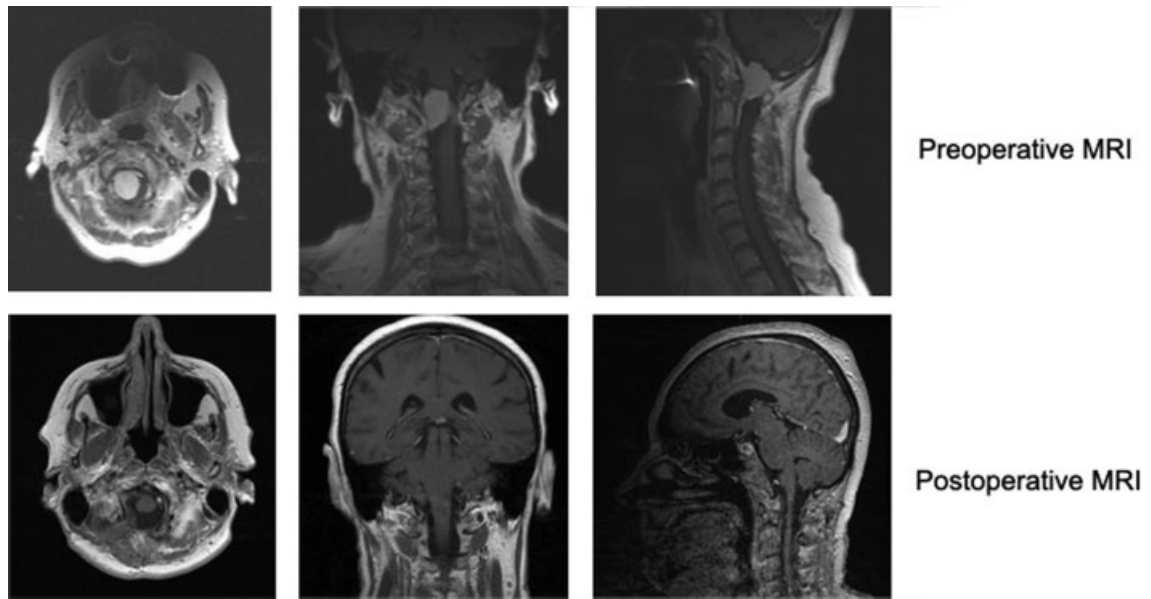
Preoperative and postoperative imaging of the foramen magnum meningioma. MRI, magnetic resonance imaging.
